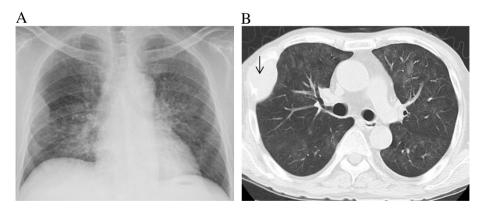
Chest radiograph (A) and chest CT (B) on the first hospital day. Diffuse ground-glass opacity with an irregular distribution without volume loss is apparent in both lung fields. Metastasis to the thoracic wall was also evident (arrow head).
